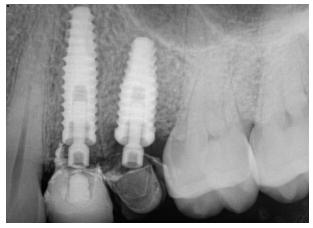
Post-insertion periapical of restored immediate implant #12 and previously placed immediate fixture #13; note PEEK abutments are completely transparent
